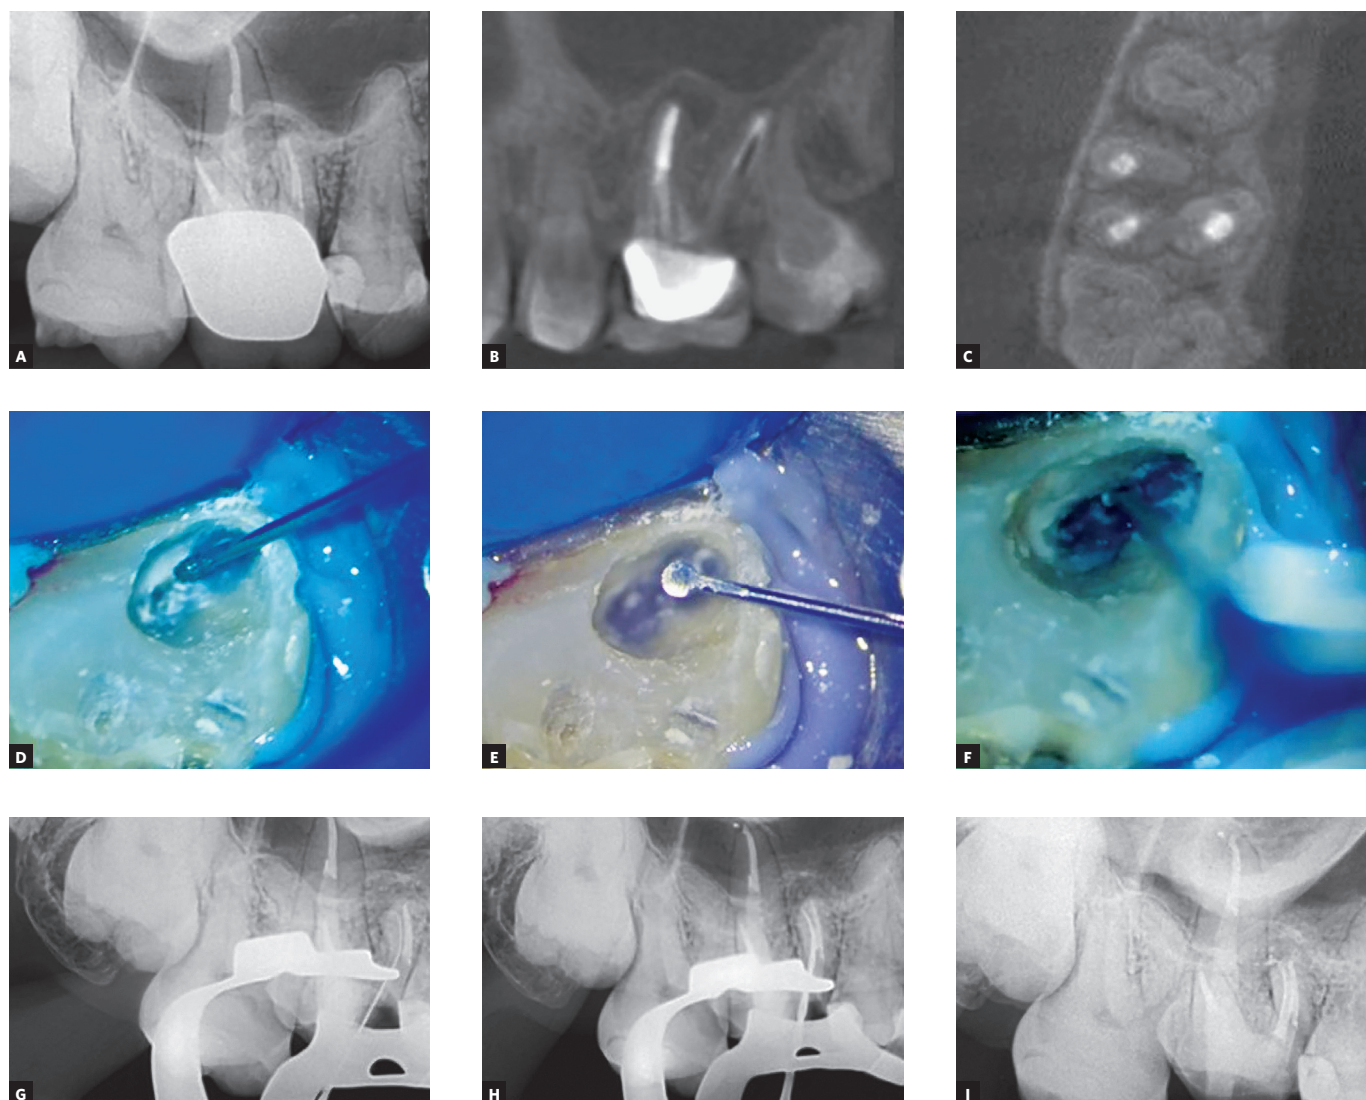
A) Diagnostic radiograph confirms failure of endodontic treatment of maxillary first molar. B) CBCT scan shows apical periodontitis in mesiobuccal root. C) Axial view shows 1MB canal in asymmetrical position, displaced buccally, which suggests presence of 2MB canal. D) Finder in position to remove dentin ledge on mesial chamber wall, whose color is different from that of the pulp chamber floor. E) Active FlatRound insert tip. F) Apical troughing removes obstacles to negotiate 2MB canal. G) C-pilot file used to explore 2MB canal after troughing. H) 2MB canal after preparation. I) 2MB canal after filling.
